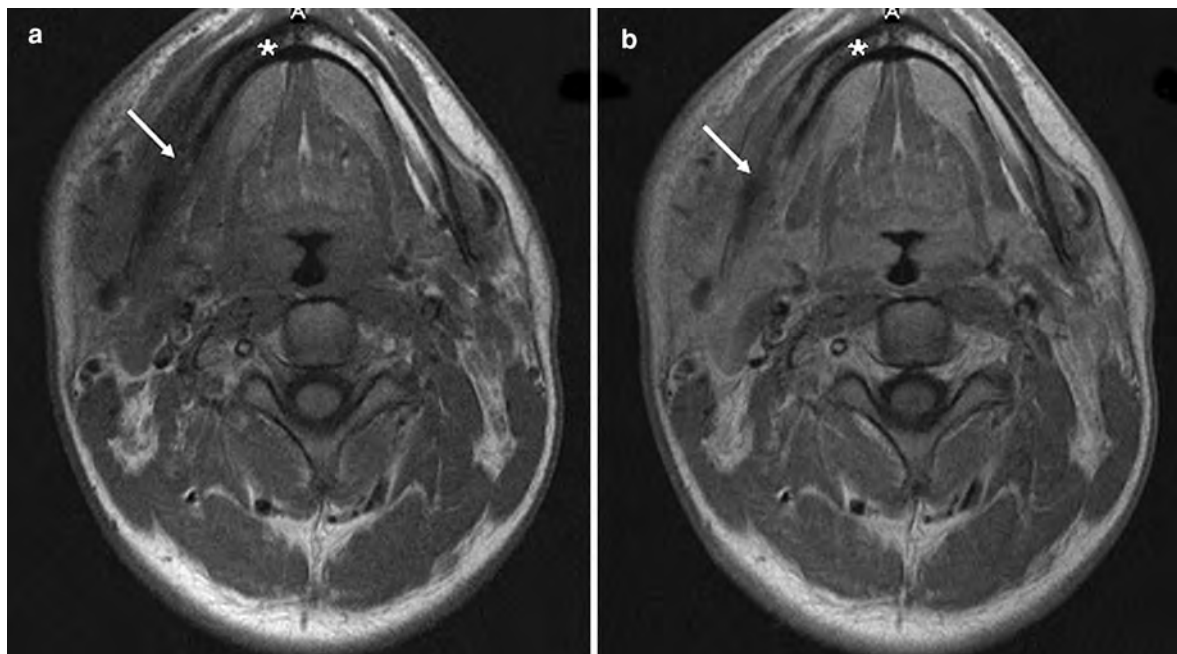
Axial MRI of a 23-year-old man with multifocal osteomyelitis (Sapho-Syndrome). The pre-contrast (a) as well as the post-contrast (b) images show a diffuse (contrast enhancing) lesion within and on both sides of the mandible.
